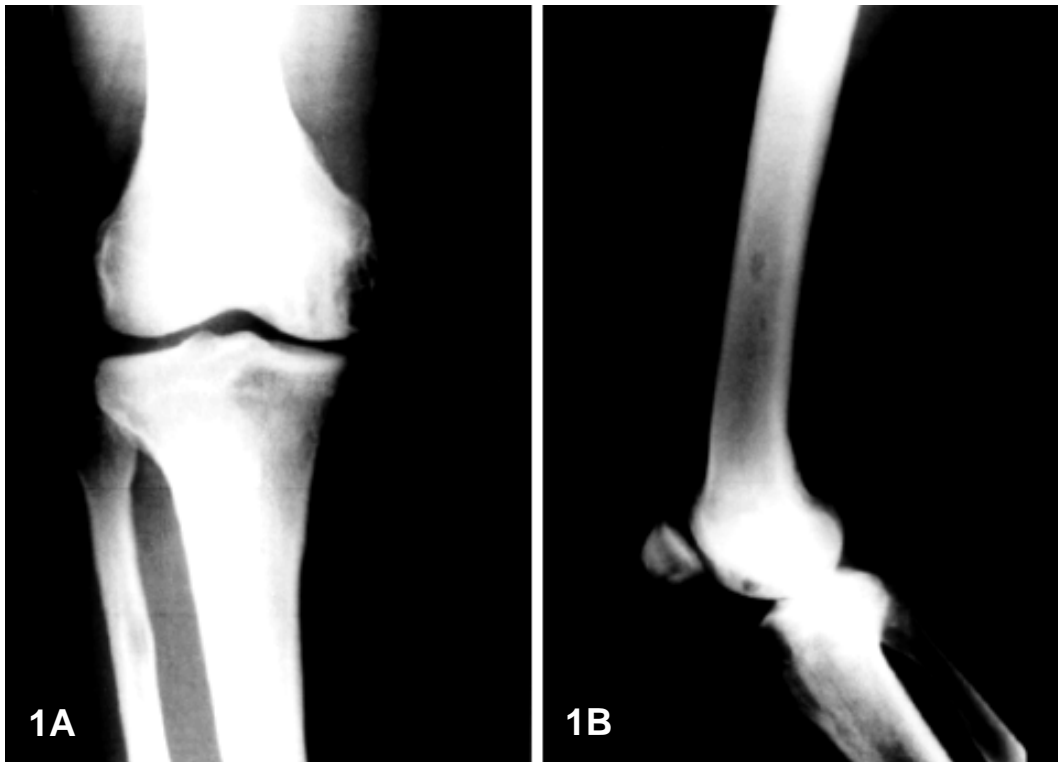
Plain radiographs. A: Lesions in a honeycomb pattern in the epiphysis of the right femur and in the right fibula. B: In the lateral view, lesions of the right femoral shaft, the right epiphysis and the right patella are punched out.
